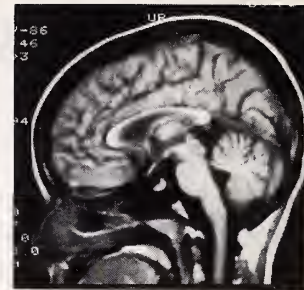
T1-weighted image demonstrating thinning of the corpus callosum.
